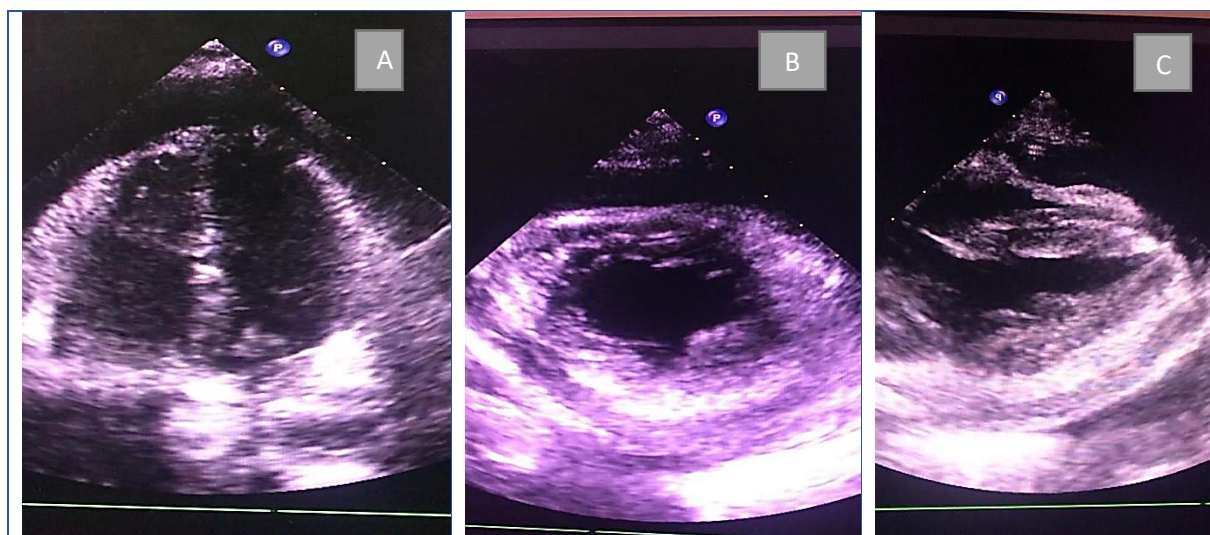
2D echocardiography. A: apical chamber view B: parasternal short axis view C: parasternal long axis view showing large pericardial effusion
